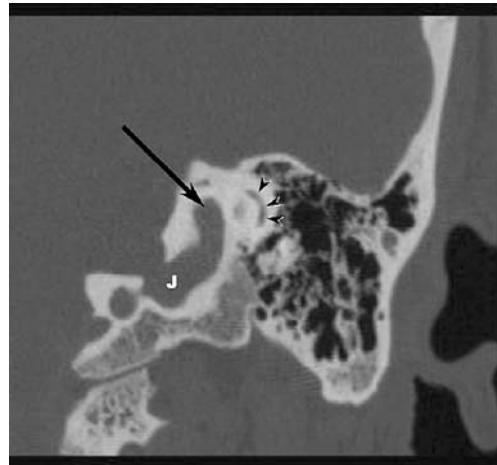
Aberrant (high-riding) jugular bulb. Coronal bone-window CT demonstrates an extension (arrow) of the jugular bulb (J) superiorly into the petrous portion of the temporal bone. This high-riding bulb extends above the level of the posterior semicircular canal (arrowheads)
